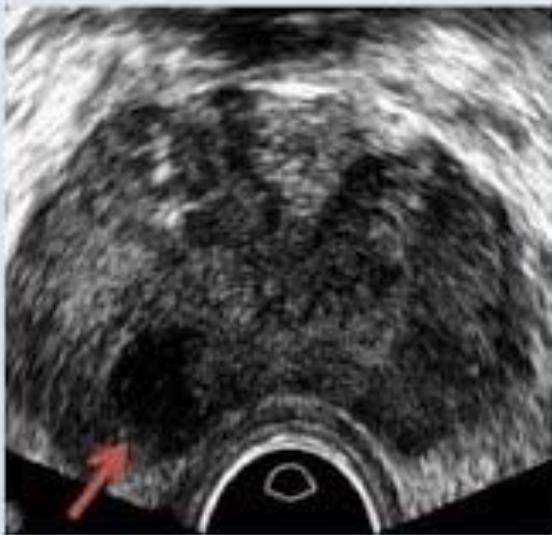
Transverse gray-scale sonogram shows large hypoechoic lesion (red arrow). Power Doppler shows increased flow within and around hypoechoic lesion (blue arrow).
